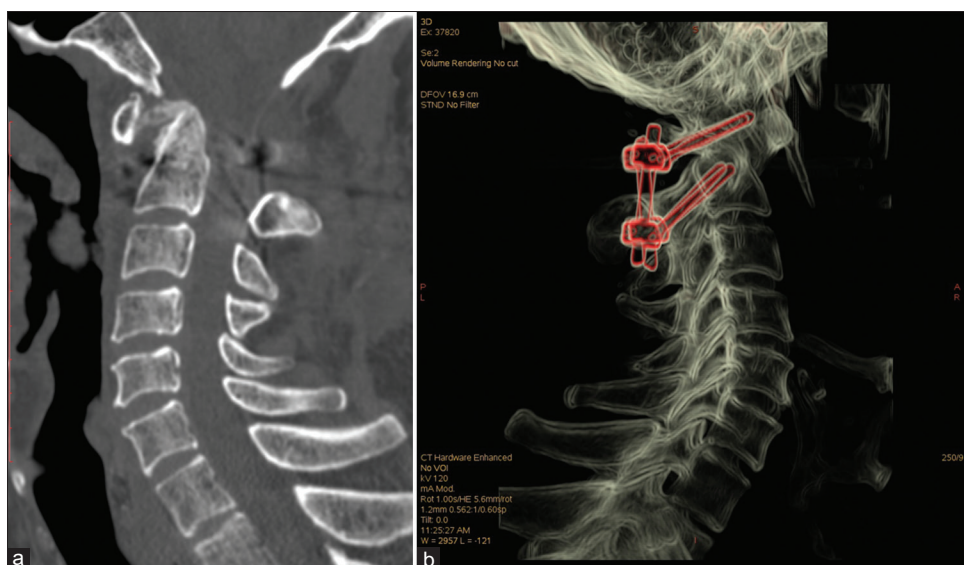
(a) Corresponding postoperative sagittal computed tomography (CT) (bone) – adequate decompression of the cervical spinal canal in comparison to the preoperative scans. (b) Postoperative CT reconstruction – C1 lateral mass screws and C2 isthmus/pedicle instrumentation.
